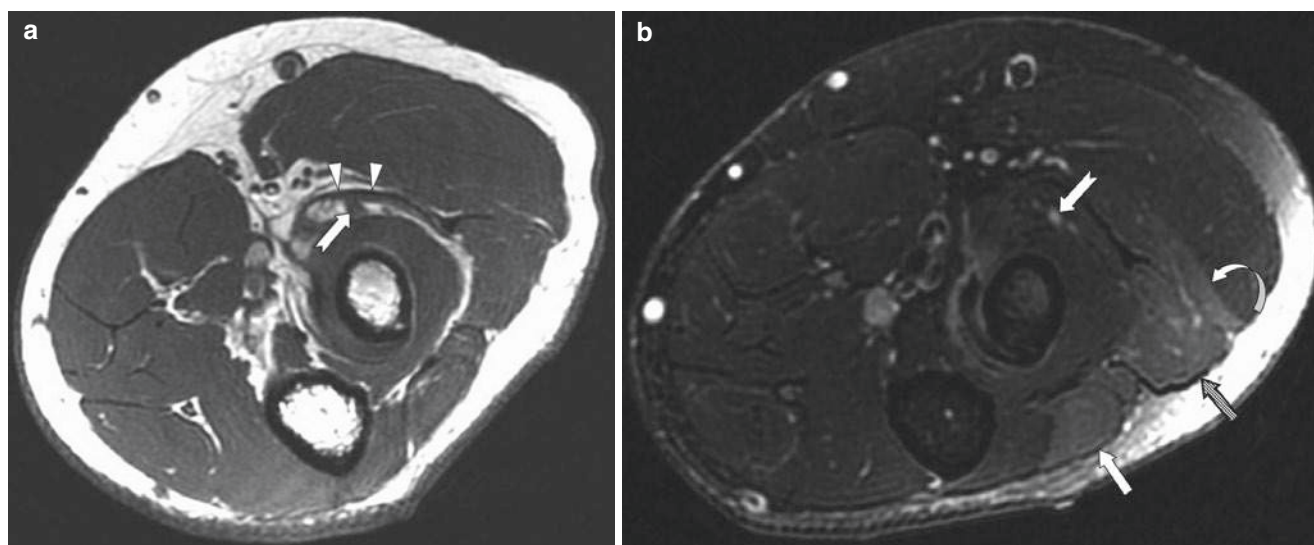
(a, b) 46-year-old woman with “wrist drop” on exam and posterior interosseous nerve (PIN) abnormality on nerve conduction study. (a) Axial T1-weighted image shows the “Arcade of Frohse” fibrous proximal edge of the superficial head of the supinator muscle (arrow-head), and the PIN (notched arrow). (b) Axial T2-weighted FS image
